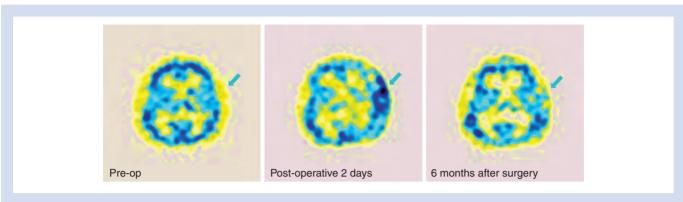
Cerebral hyperperfusion at STA-MCA anastomosis area (arrows) on brain SPECT is shown on postoperative 2 days and then disappears 6 months after surgery.
